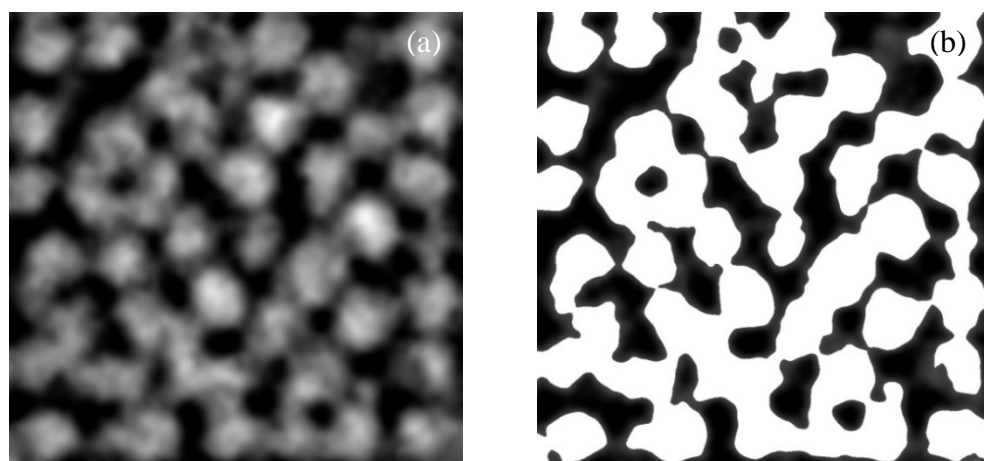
Typical images of a cross-section of a  $\mu\text{PB}$  composed of near-monodisperse 30.5  $\mu\text{m}$  diameter particles of high sphericity as derived from X-ray microtomography: (a) raw greyscale image; and (b) a binarized version of the raw image obtained using the Otsu automatic thresholding algorithm.
